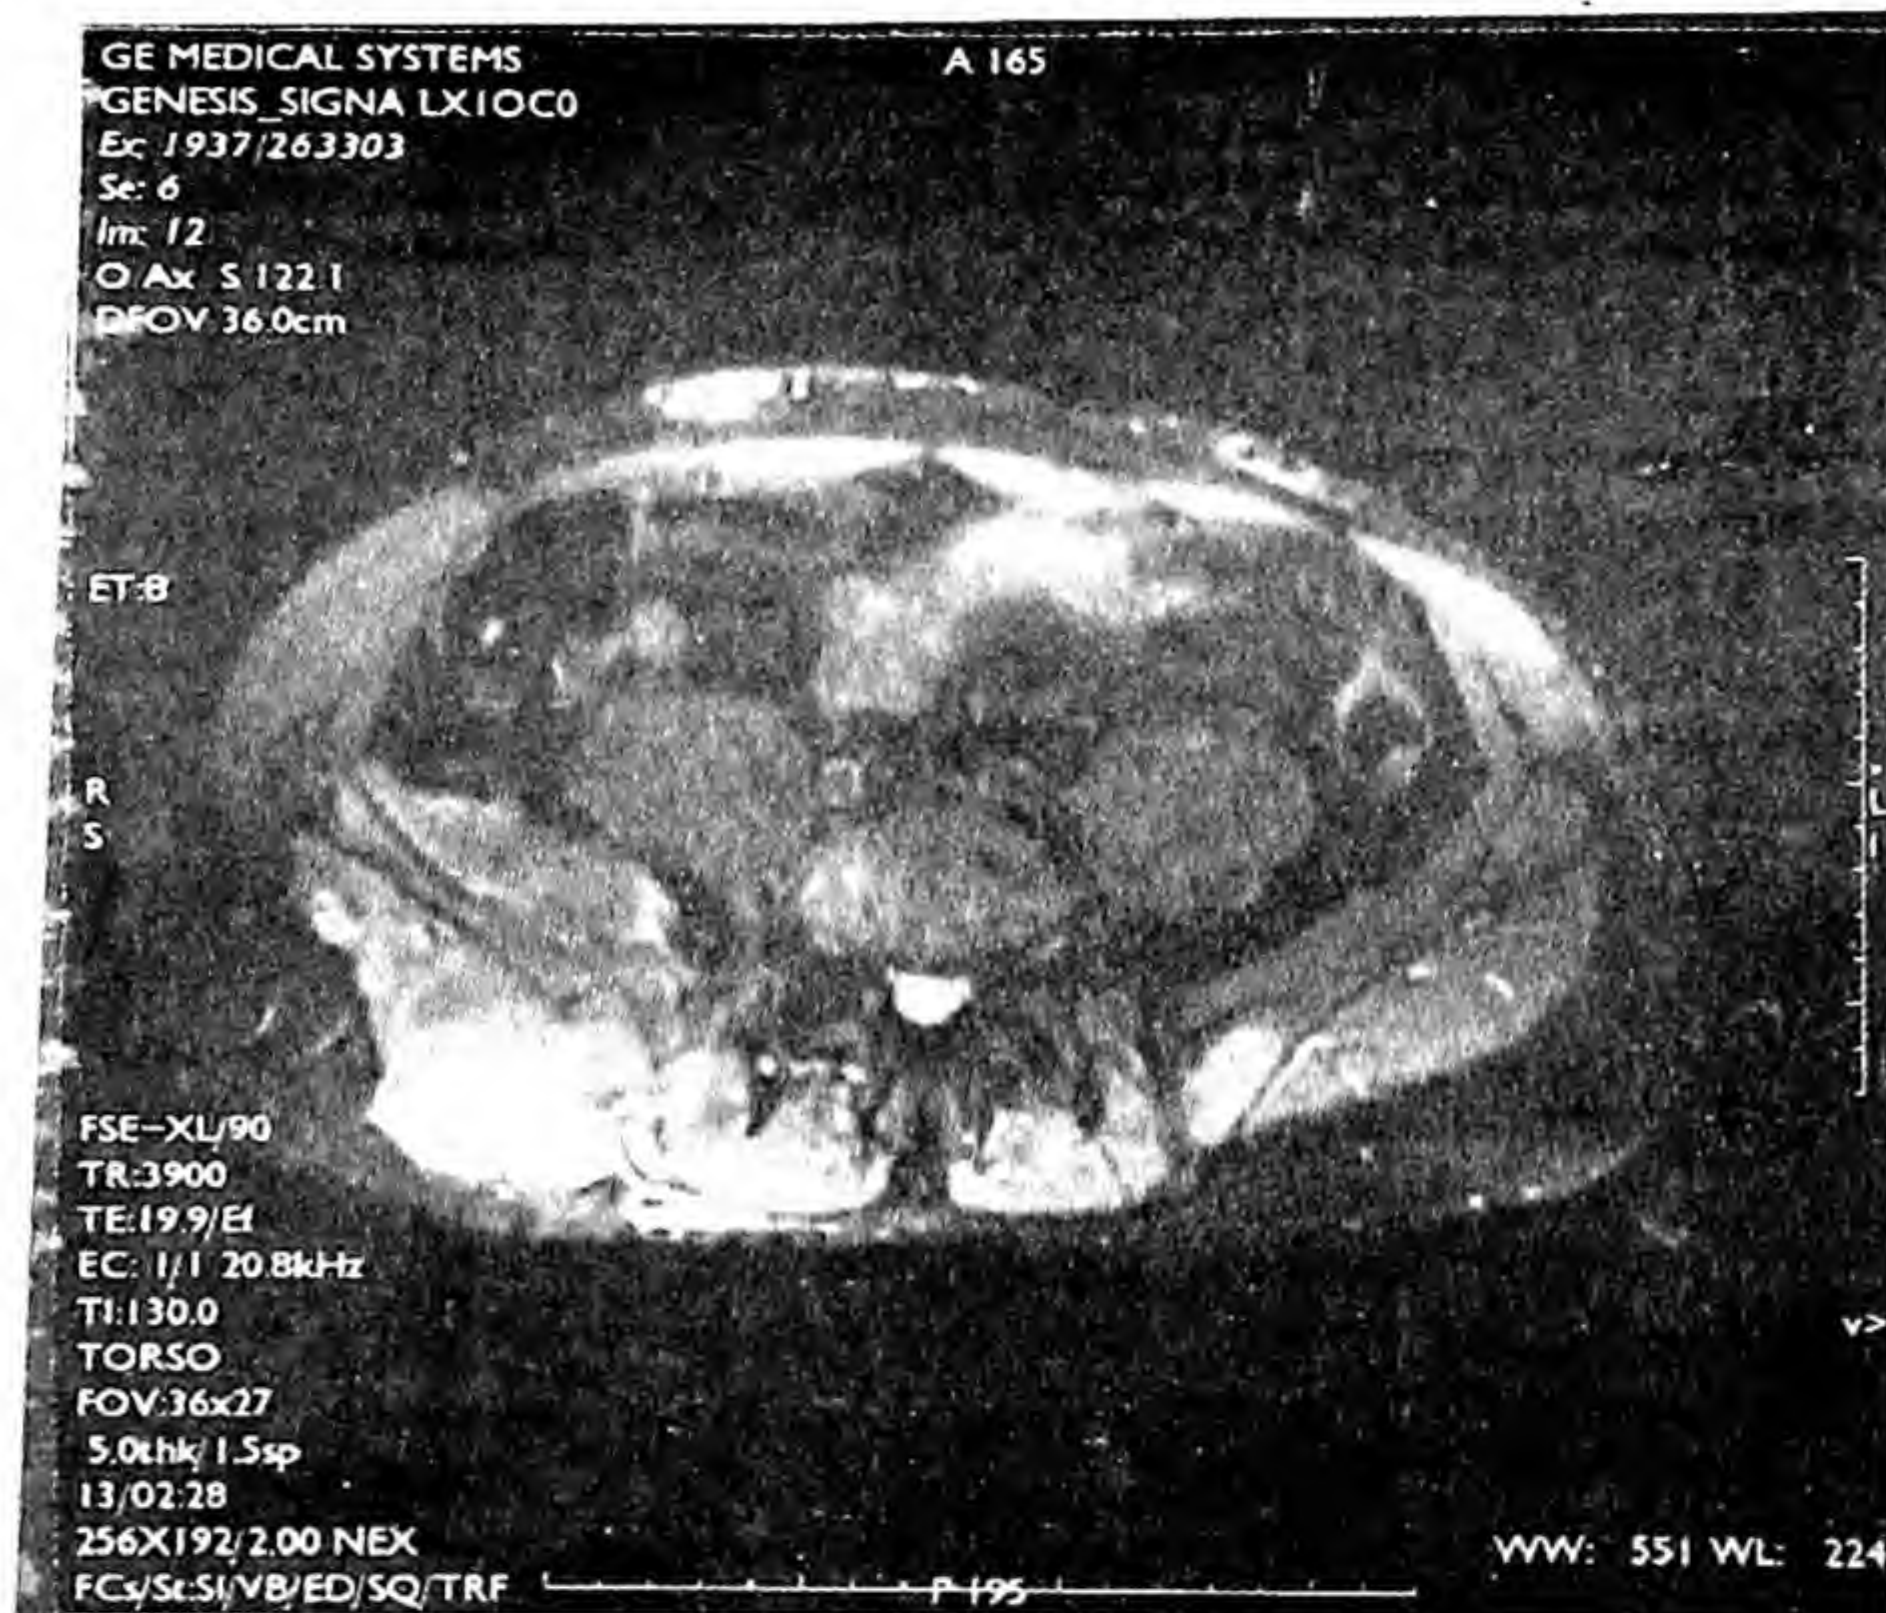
MRI scan of pelvis showing involvement of pelvic muscles
